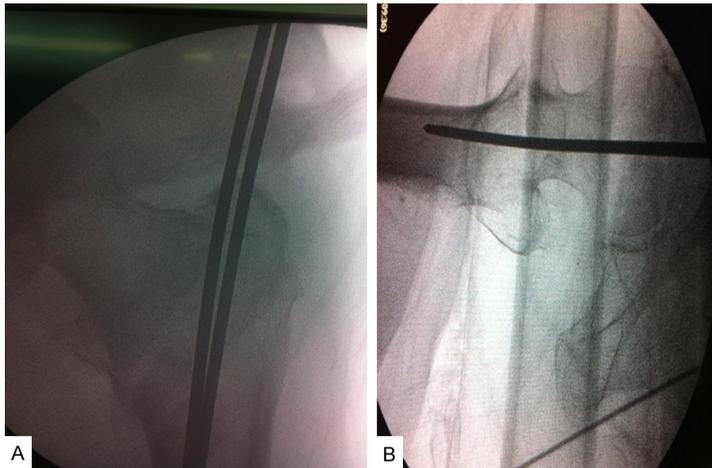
A. Anteroposterior radiograph. The guided pin insertion entry portal was located 0.5 mm medial to the tip of the greater trochanter on the medial edge of the greater trochanter. B. Lateral radiograph. The guided pin insertion entry portal was slightly posterior and in the center of the femoral neck.
